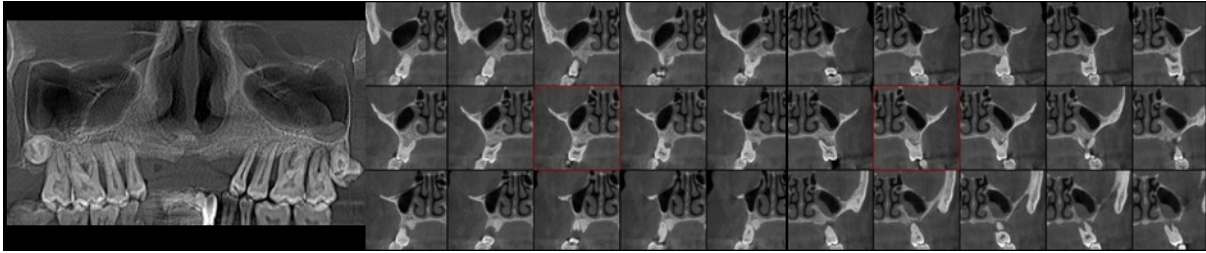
Initial computed tomography with coronal and cross sections
